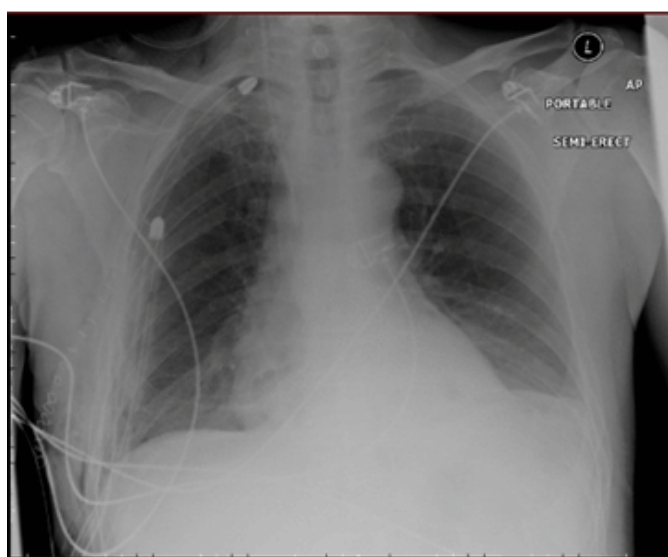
Chest X-ray taken on the first postoperative day. An apical and basal chest drain is in situ in the right hemithorax, which has a small residual pneumothorax. There is a small pleural effusion in the left hemithorax.
